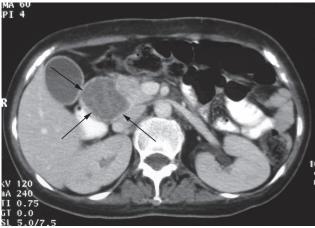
Glucagonoma in a 43-year-old female who presented with skin rash and DM. CT shows a cystic mass at the pancreatic head (arrows).
